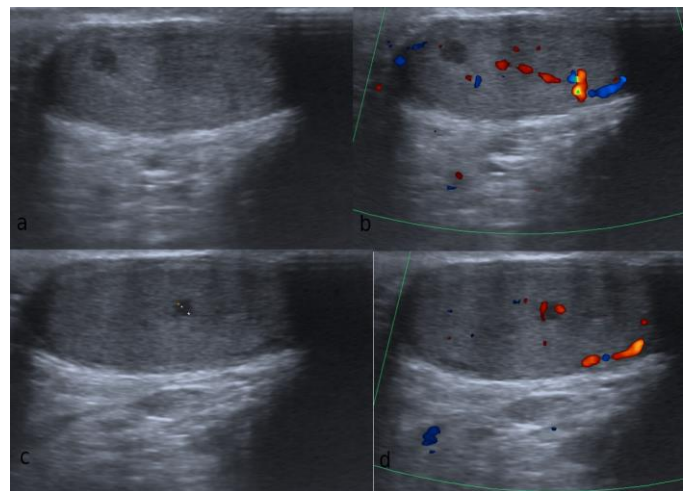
Ultrasound appearances of the left testicle (a and c: left testicular nodules b and d: colour doppler appearances of left testicular nodules).
